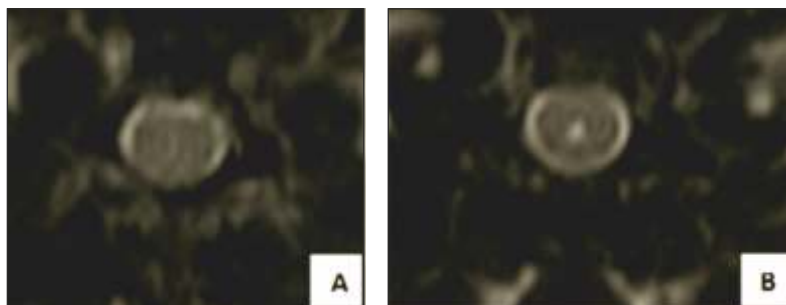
T2-weighted MRI image of the spinal cord, transvers plane. A – Normal spinal cord (Grade 0 SM); B – Central canal dilatation (Grade 1 SM)
